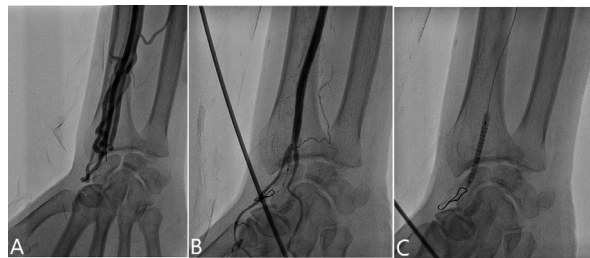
A: Vascular ultrasound showing high flow continuous turbulence, and vein dilation multiple fistulous communication; B: Complete exclusion of RAVF with visible stent in the lumen
